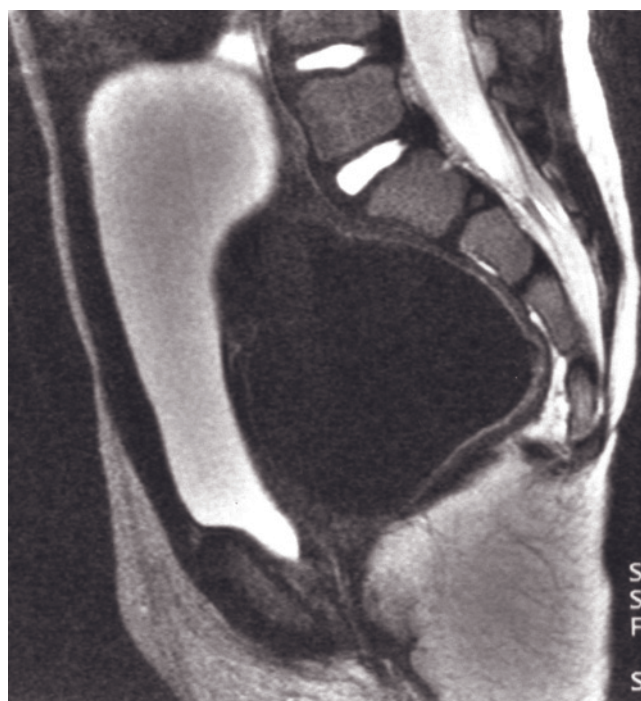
Surgical repair of persistent cloaca. Sagittal T1-weighted spin-echo (*a*), sagittal T2-weighted echo-train spin-echo (*b*), and transverse T2-weighted echo-train spin-echo (*c*) images. A capacious neorectum (*r*, *a-c*) is present. The bladder (large arrow, *a-c*) is thick-walled and anteriorly displaced. Absence of the vagina is noted. Sagittal T2-weighted SS-ETSE (*d*) and T1-weighted SGE (*e*) images in a second patient with cloacal anomaly who had undergone multiple surgeries. The levator ani complex is diminutive in size, and distal sacral segments are absent. There is a fluid-filled structure situated posterior to the uterus that represents the anal canal and rectum.
